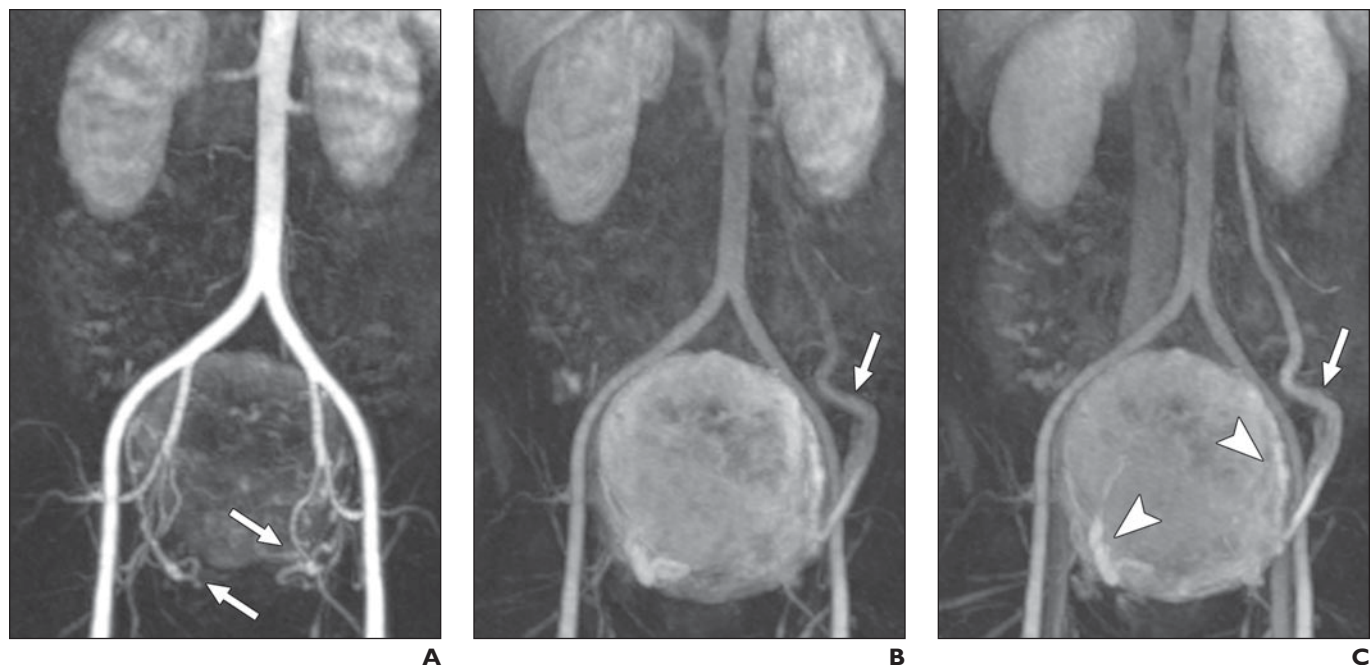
Time-resolved MR angiography (TR-MRA) in 37-year-old woman with uterine leiomyoma and antegrade flow through dilated ovarian vein. A, Coronal maximum-intensity-projection (MIP) image obtained during arterial phase shows prominent and tortuous uterine arteries (arrows). B, Coronal MIP image obtained during late arterial phase shows parenchymal enhancement of uterine leiomyoma and early antegrade filling of dilated left ovarian vein (arrow). C, Coronal MIP image obtained during venous phase shows continued antegrade flow via dilated left ovarian vein (arrow). Periuterine varices are present (arrowheads). Note overall similar appearance of A and C compared with Figures 1A and 1C, in which determination of direction of flow is difficult or impossible given only those images. This figure underscores utility of TR-MRA for evaluating ovarian vein reflux when compared with CT or static MR angiography imaging, even with use of multiple phases of contrast enhancement.
